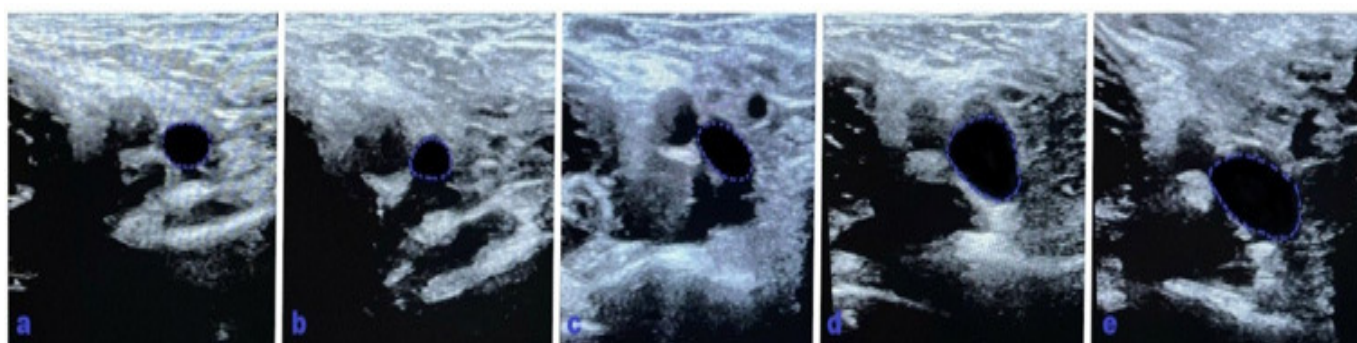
Figure a, b, c, d, e. Ultrasonographic scans showing femoral vein cross-sectional area measurements of volunteers in five different body positions: supine (a), Trendelenburg (b), reverse Trendelenburg (c), frog leg (d), reverse Trendelenburg+frog-leg position (e).
